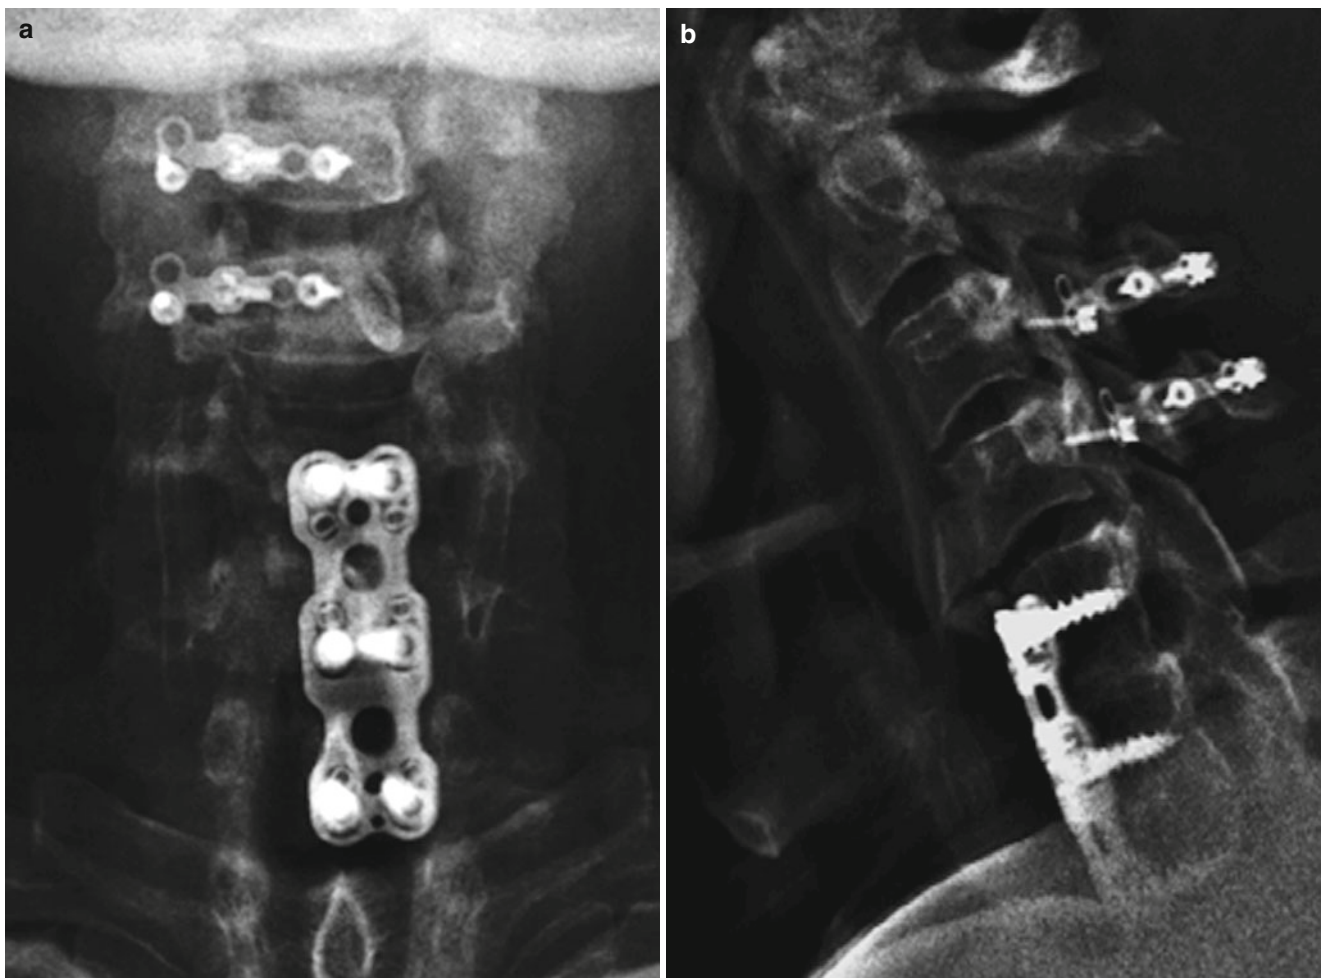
(a–c) Postoperative radiographs
